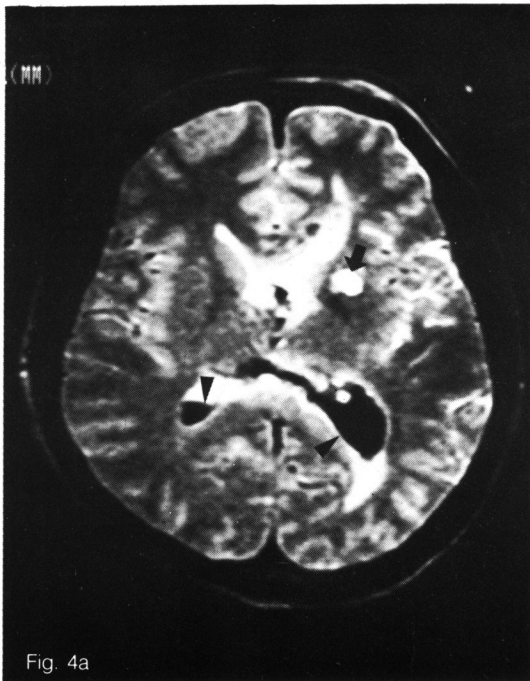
Axial MR images (SE 2500/80/1) of intraventricular hemorrhage and ischemic infarcts in watershed areas. There are multiple areas of high intensity in periventricular white matter on left side, indicating ischemic infarcts (arrows), and low signal intensity within the lateral ventricle representing acute hematoma (arrowheads).
